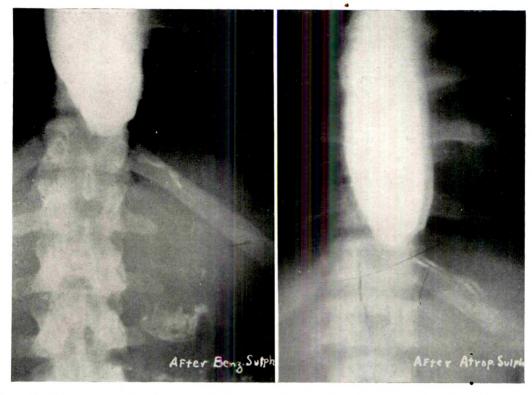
Cardiospasm, unaffected by benzedrine or atropine. A. B., male, aged twenty-three. Has suffered with severe dysphagia for seven years. Occasional periods of partial relief, but is never completely free of symptoms. Bougies have been passed with slight temporary improvement. Roentgen examination revealed marked dilatation of the esophagus with stenosis of the lower end. After the administration of benzedrine and atropine sulphate, there was no relief of the operation.
